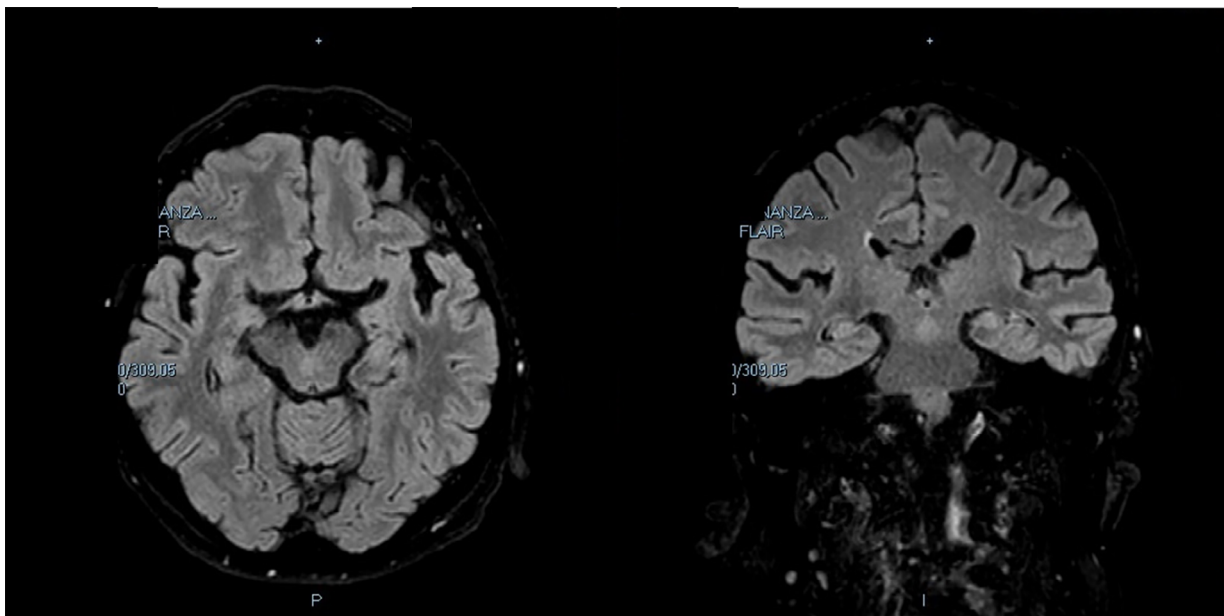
Brain MRI showing a mild diffuse subcortical atrophy particularly involving the temporal lobes.
